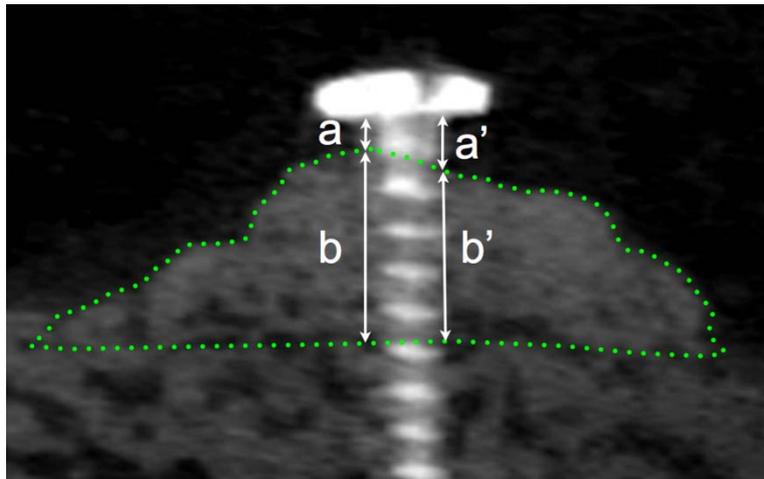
Radiographic measurements. Cross-sectional bone area (mm^2): area surrounded with green dots. Residual bone height (%) = $100 \times b/(a+b)$; $(a+b)$ = distance from the bottom of the screw head to the recipient bed, b = distance from the recipient bed to the highest contact point of the residual graft and the screw. The opposite side of the screw was also measured (a' , b').
